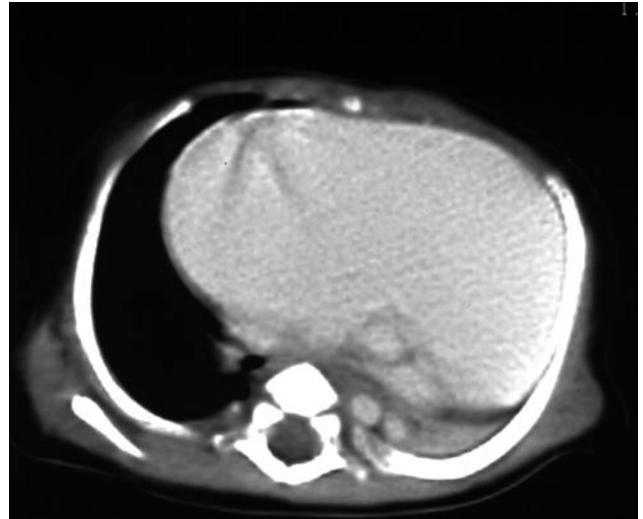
CT scan of the same patient showing the extent of the diverticulum and the left lung depressed by it
